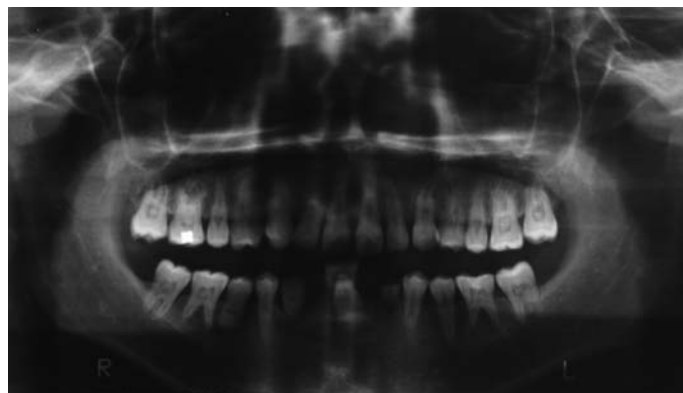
Panoramic radiograph at two year follow-up with pulp stones obliterating pulp chambers in nearly all teeth.
